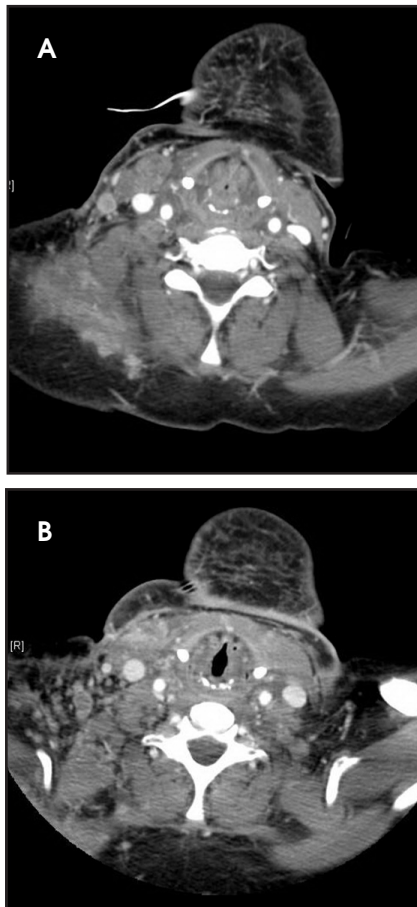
A CT scan with contrast (A) showing a patent airway prior to the administration of gemcitabine. Approximately 3 weeks later, (B) a scan shows near obstruction of the airway due to edema.
